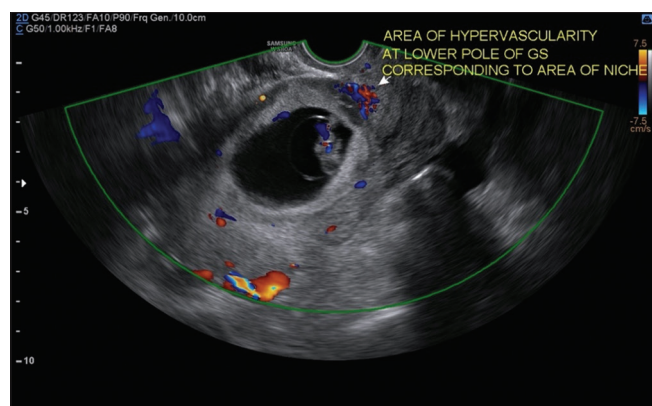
Transvaginal ultrasound image showing the area of hypervascularity at the lower pole of the gestational sac corresponding to the area of the niche
